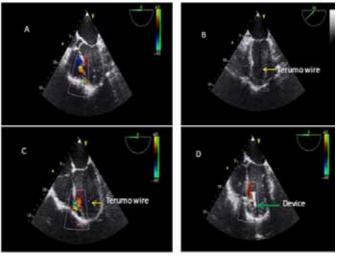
Deployment of Amplatzer post-infarct muscular device by perventricular approach under transesophageal echocardiography (TEE) guidance. (A) Left to right shunt across the ventricular septal defect (VSD), (B) Terumo wire in left ventricle (yellow arrow), (C) Terumo wire in left ventricle across the defect (yellow arrow), and (D) No left to right shunt across the defect after device deployment (Device: green arrow)
